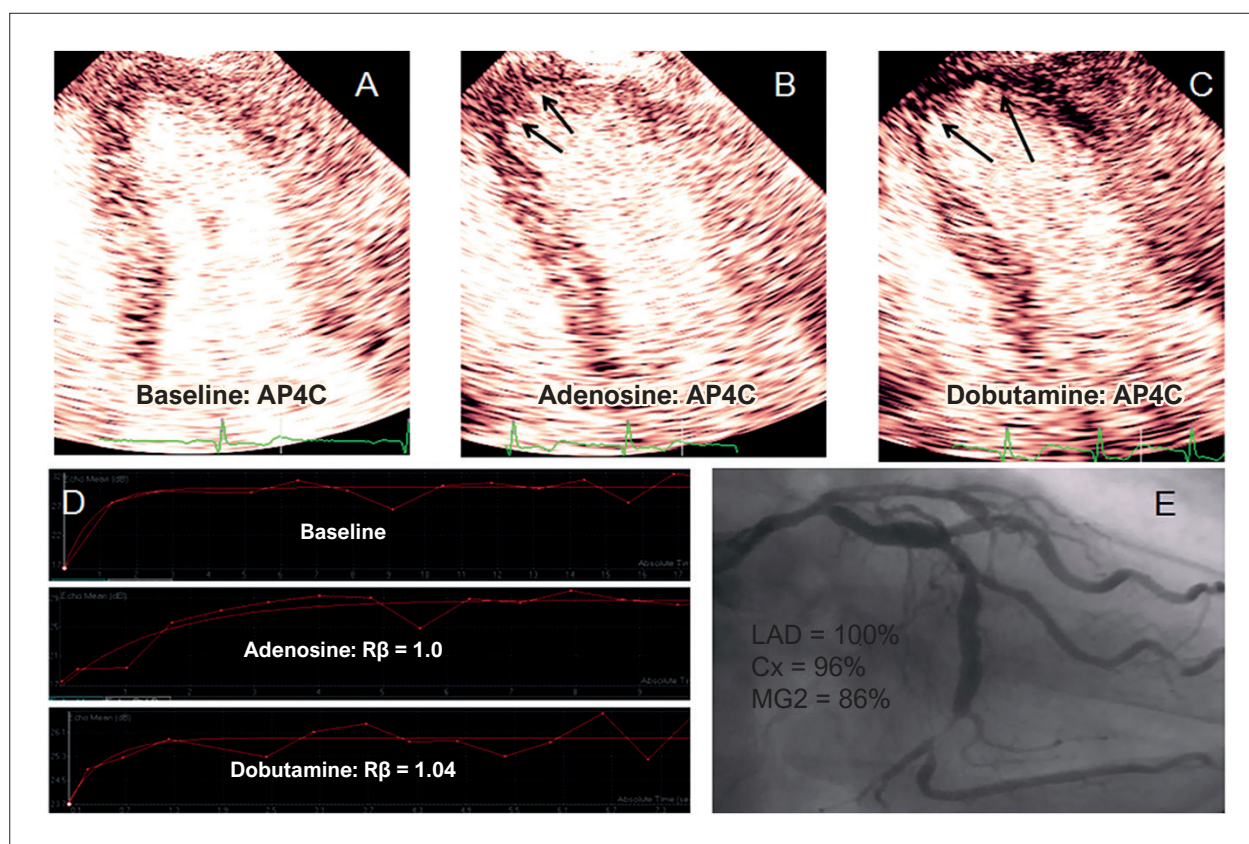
Apical four-chamber view from two pharmacologic stress studies in the same patient using microbubble contrast to assess myocardial wall motion and perfusion. (A) Normal perfusion at rest. (B) Transmural perfusion defect in a single apical segment during adenosine stress. (C) Extensive transmural apical perfusion defect involving at least two segments, associated with wall motion abnormality (akinesia) in the same territory during dobutamine stress. (D) Acoustic intensity-time curves generated by dedicated software, demonstrating severely impaired coronary flow reserve under both stress protocols. (E) Coronary angiography in left anterior oblique view showing severe stenosis in the left anterior descending, circumflex, and marginal arteries.
